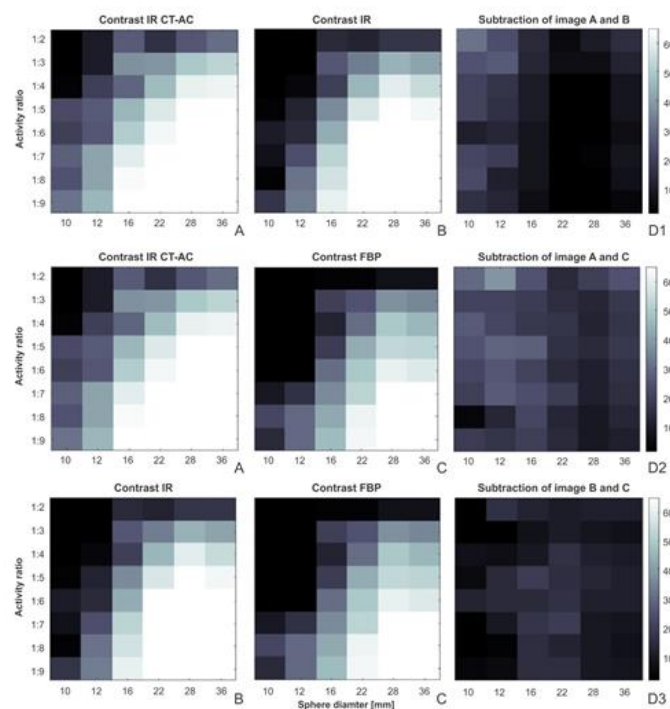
Contrast of iterative reconstruction with CT-AC (A), iterative reconstruction (B) and FBP (C). The subtraction of figure A vs B is figure D1, A vs C is figure D2 and B vs C is D3. Black colour on figure A, B and C represents a negative contrast and a contrast of less than 10%, which means that such lesions cannot be seen. Lighter colour represents a positive contrast. White colour represents the contrast, higher than 65%. The figure C represent the contrast subtraction of two different reconstructions, where the dark fields mean that there is not much difference between the two reconstructions; the brighter the fields, the greater the difference in contrast.
